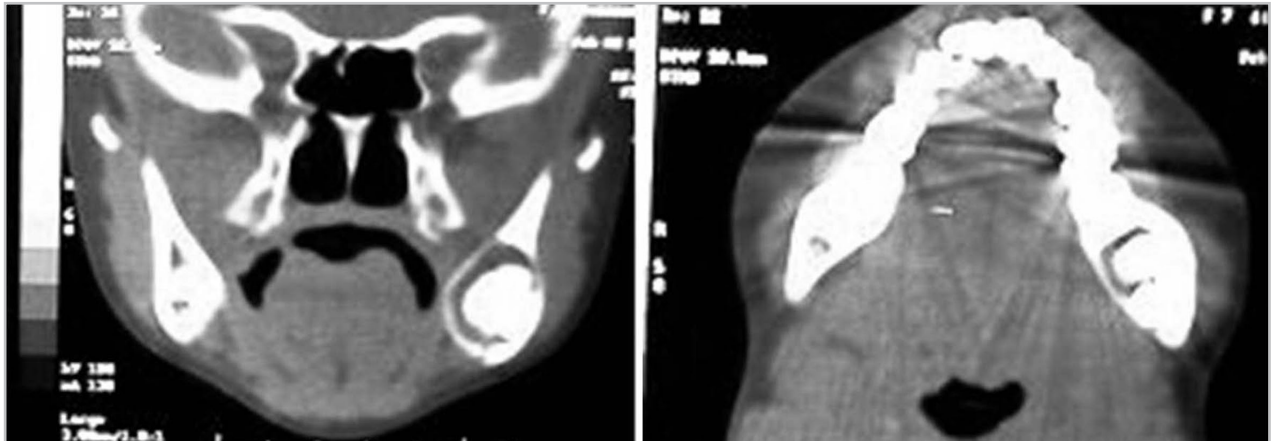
Computed tomography images (coronal and axial slices) showing hyperattenuating bone lesion bounded into the left mandibular angle.
